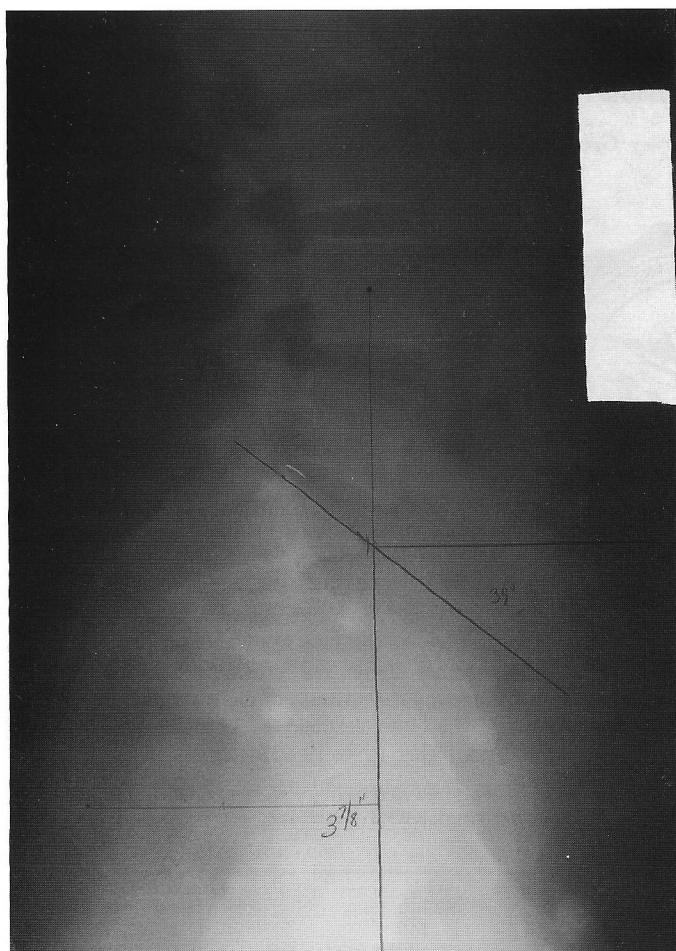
X-ray taken on February 23, 1989 that shows sacral displacement posterior to the weight-bearing line.
